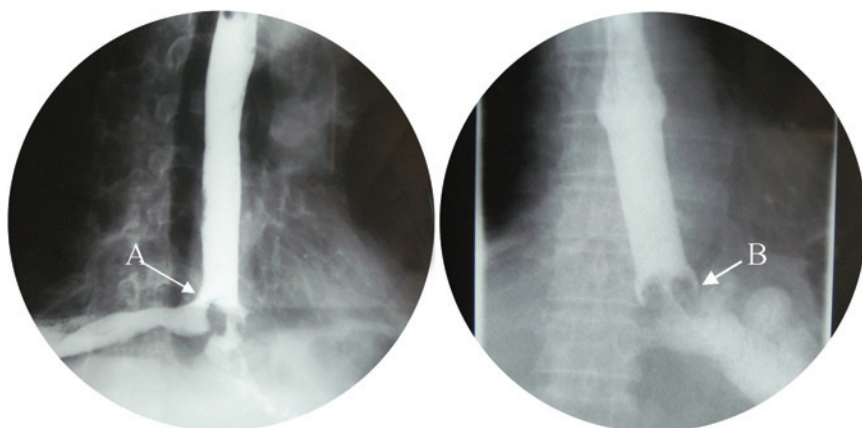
Contrast radiography performed on day 18 after the surgery (A), and on day 4 after insertion of the metallic stent (B). The fistula stoma is present in the image A (arrow A), but not seen in the same position in image B. In image B, since the horn shaped end of the stent (arrow B) does not exactly match with the jejunum, refluxed fluid enters the gap between the stent and jejunal wall. So, there was still a small amount of fluid observed to flow into the thoracic cavity when contrast radiography is dynamically monitored, although the fistula stoma is not seen in the static image.
